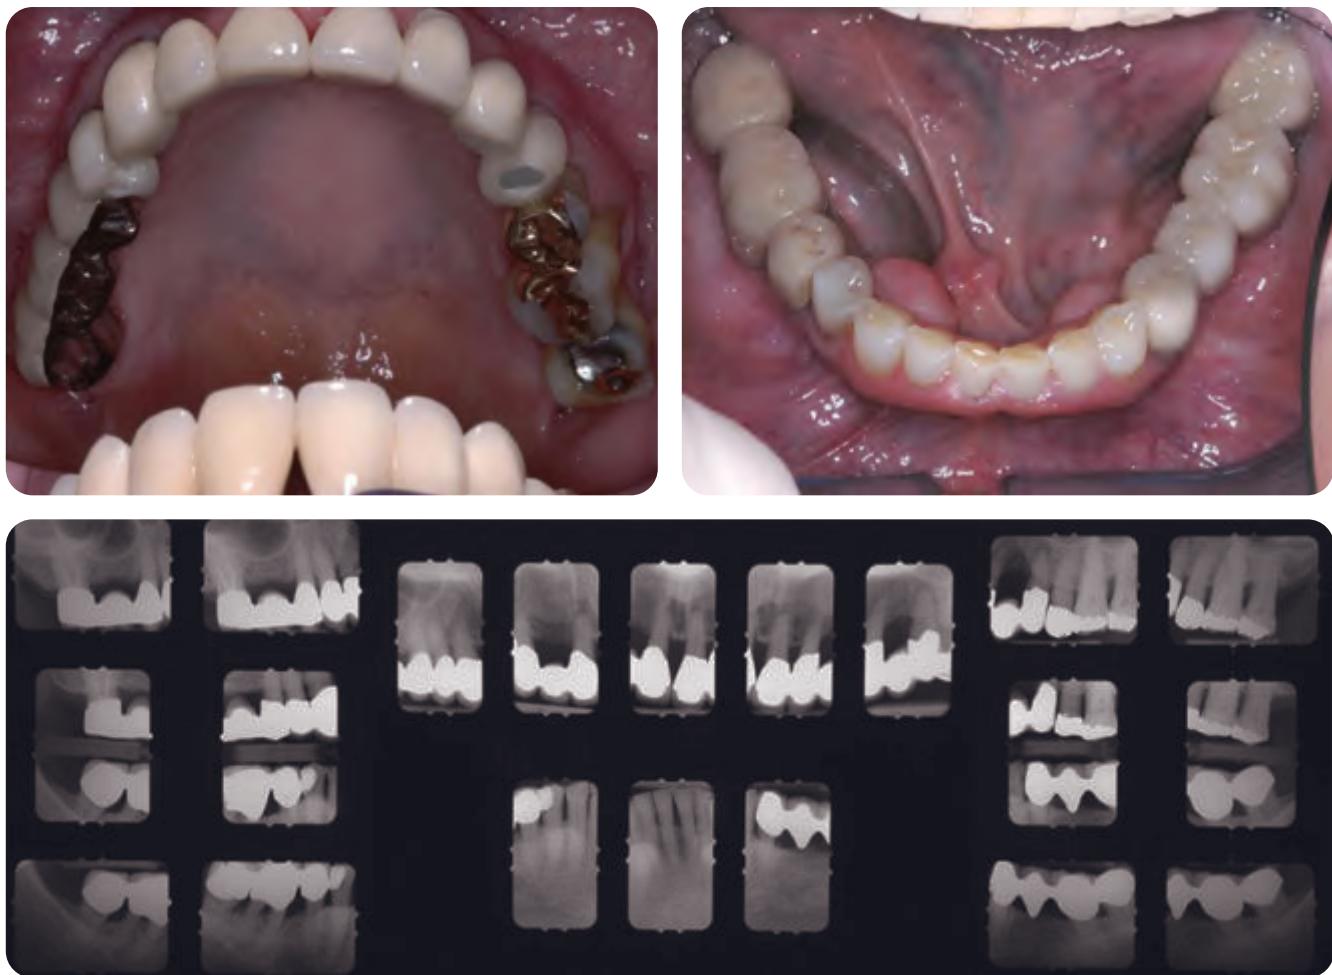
Pretreatment occlusal photographs and full mouth radiographic series.
